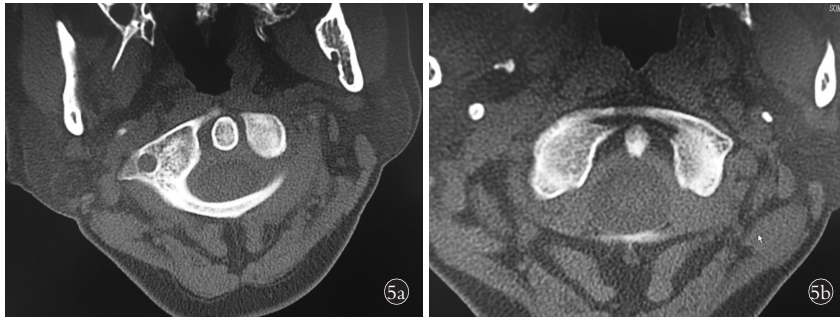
女性患者,53 岁,外伤致寰枢椎关节半脱位 5a. 治疗前 CT 示寰枢椎间隙不对称,右侧约 6 mm,左侧约 2 mm 5b. 经过 3 个月的牵引治疗后复查 CT 示寰枢椎间隙左右对称,疼痛缓解,活动自如
